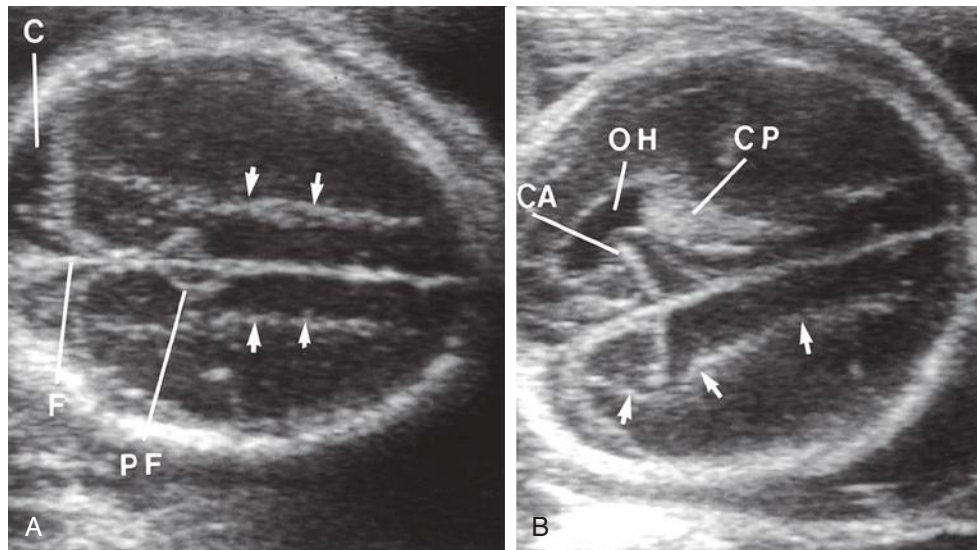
A, Transverse axial sonogram near the vertex. Bright linear echoes (*arrows*) often mistaken for lateral ventricles are clearly seen. Note that these echoes extend to the brain edge. C, convexity cistern with cerebrospinal fluid and hair-like bridging veins covered by brightly echogenic pia-arachnoid; F, falx; PF, parieto-occipital fissure. B, Off-axis scan through both the lateral ventricle and the linear echo (*arrows*) seen in A. The occipital horn (OH) is now well seen. Note again that the linear echo extends to the brain edge, whereas the occipital horn is entirely margined by brain tissue. CA, calcar avis; CP, choroid.
